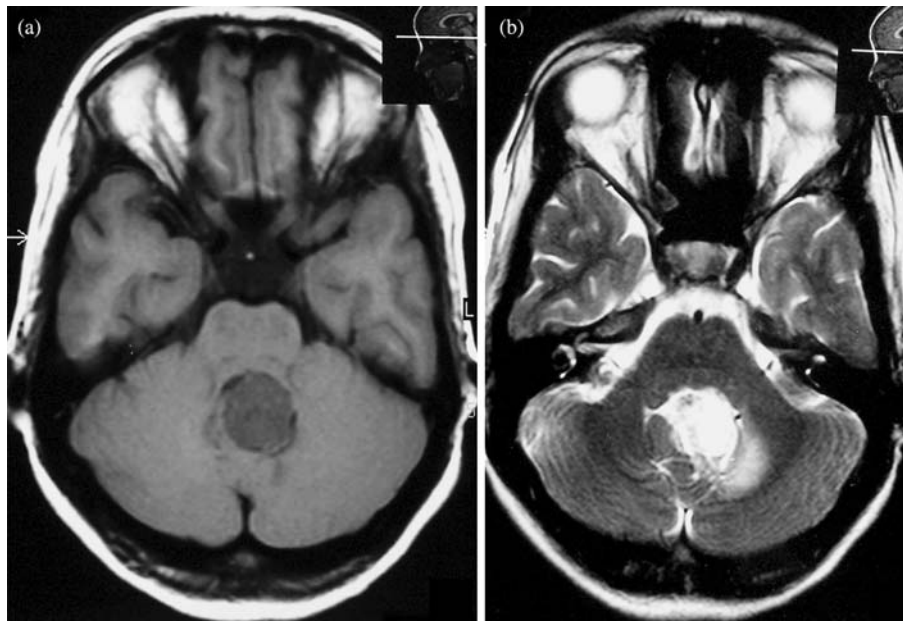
(a) MRI T1 WI of case no. 7 shows hypointense mass in the fourth ventricle. (b) The tumor is hyperintense on T2 WI.
